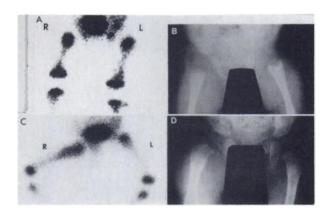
Neonatal osteomyelitis of both proximal femurs in 42-day-old male (A) Delayed bone scan of the legs is normal in spite of (B) radiograph showing bone destruction with extensive periosteal new bone formation. Compare with (C) obvious radioactive increase in proximal right femur secondary to osteomyelitis in 60-day-old male with (D) radiograph also demonstrating bone destruction and periosteal new bone formation.
